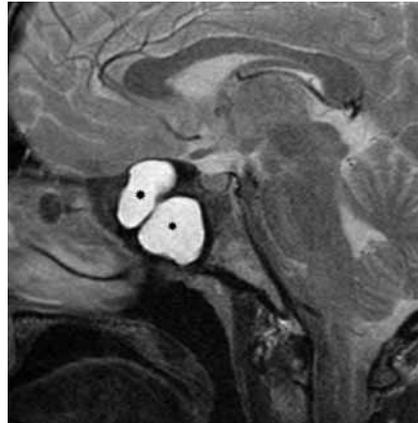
Sagittal T2-weighted MR image. Note hyperintense expansile lesion in the sphenoid sinus (asterisk).
